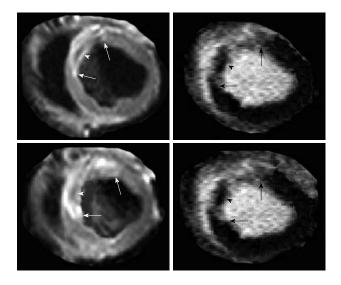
Multi-slice T2-weighted turbo spin echo imaging demonstrates the hyperintense edematous area at risk (white arrows in the left images) with hypoenhanced zone, which may represent microvascular and/or interstitial hemorrhage zone (arrowhead in the left images). Delayed contrast enhancement magnetic resonance (DE-MR) imaging confirmed the presence of microvascular and/or interstitial hemorrhage zone in the core (black arrowhead in the right images) of hyperenhanced infarcted myocardium (black arrows in the right images).
